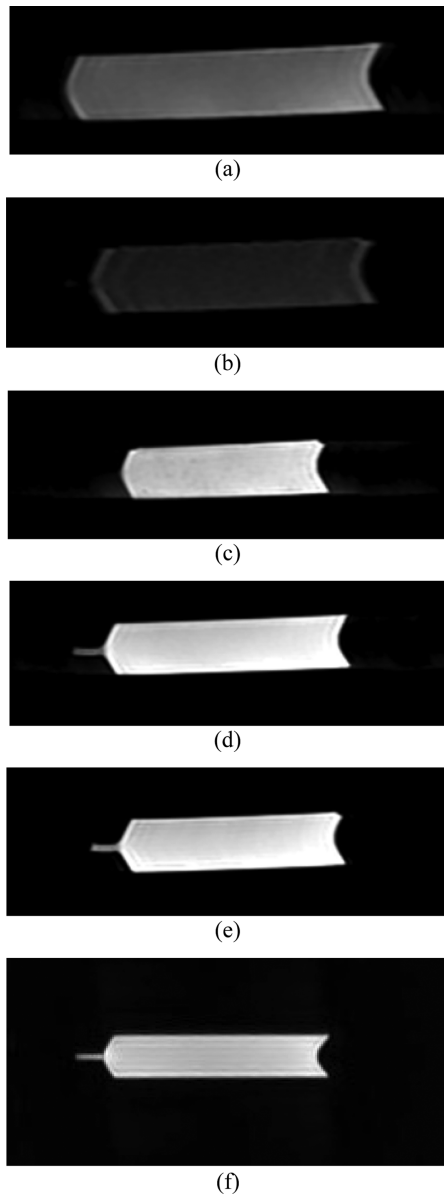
Each contrast media was examined using a T2-weighted sequence. The contrast media used were Solotop[®] (a), Gastrografin[®] (b), 50 % blueberry juice (c), 100 % orange juice (d), 3.5 % blueberry juice (e), and water (f).
